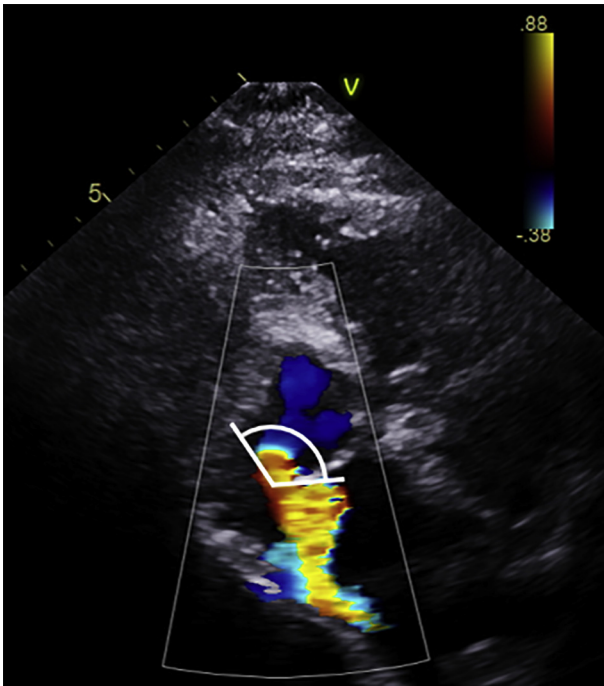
Wall-constrained posterior regurgitation flow convergence zone on color Doppler echocardiography. *White lines* indicate that the observed angle of convergence zone was reduced to 120° from its expected full hemispheric angle of 180°. Thus, the calculated EROA was reduced by one third.
